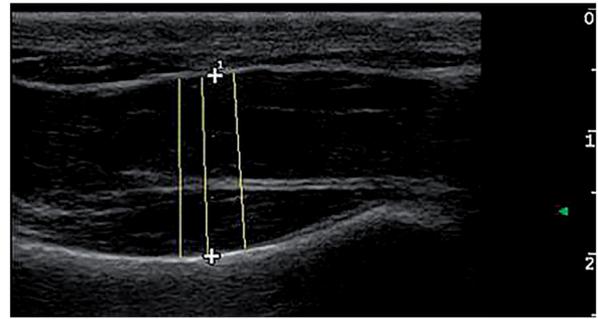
Ultrasound image of the flexor hallucis brevis with three thickness measurements (yellow lines).
